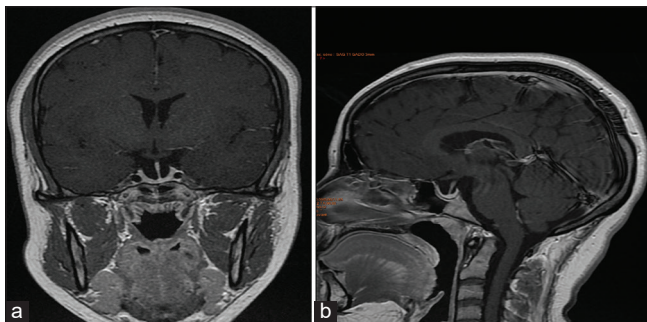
Hypothalamic-pituitary MRI of patient number 1 after corticosteroid therapy showing hypotrophy of the anterior pituitary with arachnocele. (a and b) Dynamic coronal (a) and sagittal (b) section FSE T1 after gadolinium injection.
